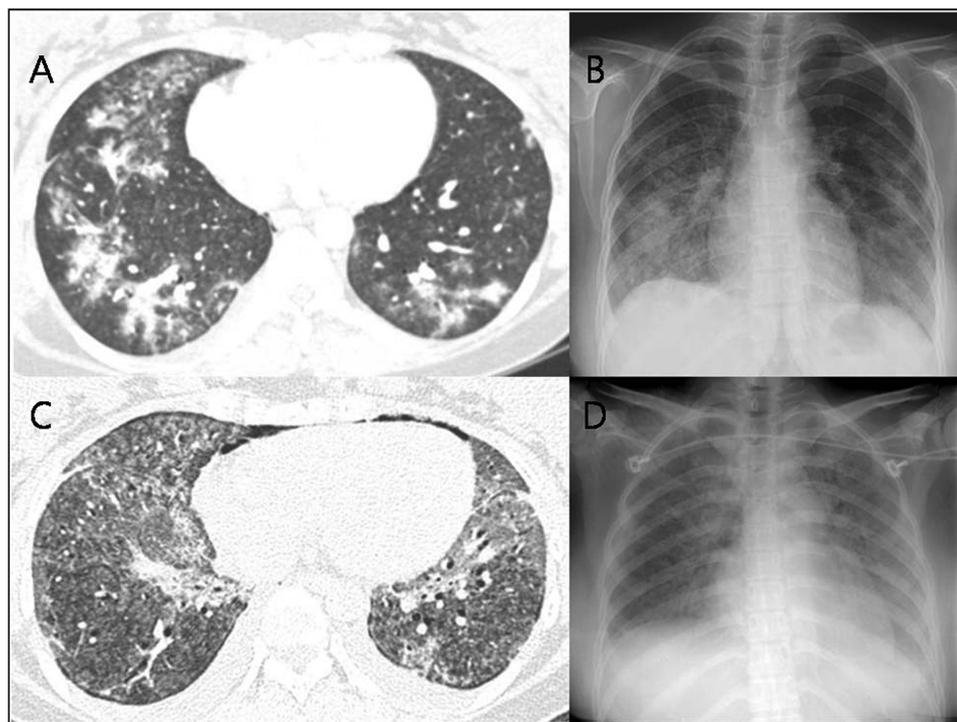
A 32-year-old postpartum woman who died of severe respiratory failure. Chest radiograph and CT images obtained on the day of the initial visit showed multifocal patchy areas of consolidation at the lower portion of both lungs, with relative sparing of the subpleural areas (A and B). On CT obtained on hospital day 8, consolidation disappeared and diffuse centrilobular ground-glass opacity nodules that involved the entire lung without zonal predominance (C and D). Small amount of pneumomediastinum is also noticeable at the anterior mediastinum (C and D).
